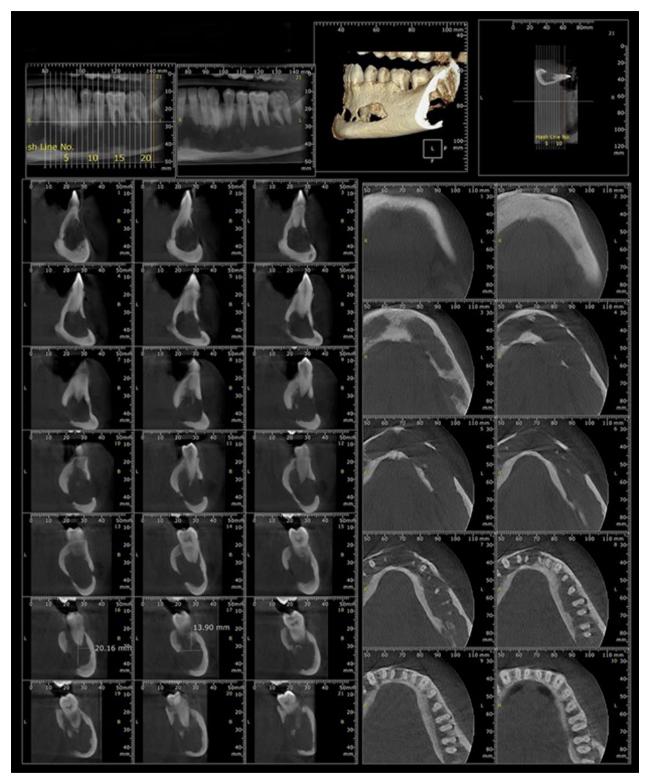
Cross sectional and axial cuts of left posterior mandible in cone beam computed tomography
